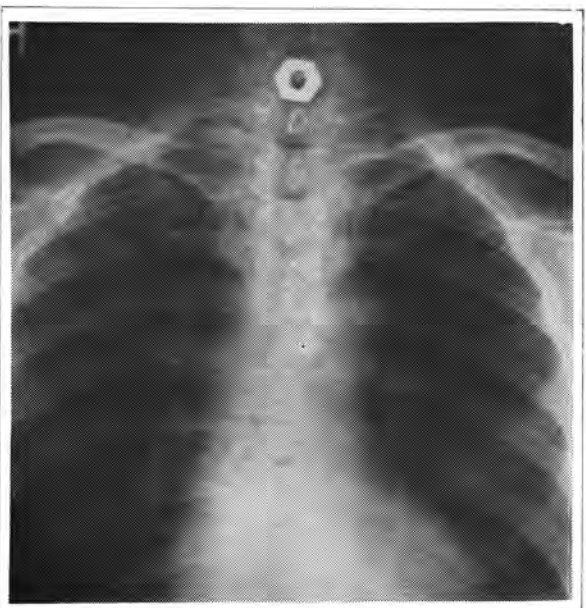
X-ray of the chest showing normal lung and heart shadows. The foreign body is seen in the trachea in the midline.
